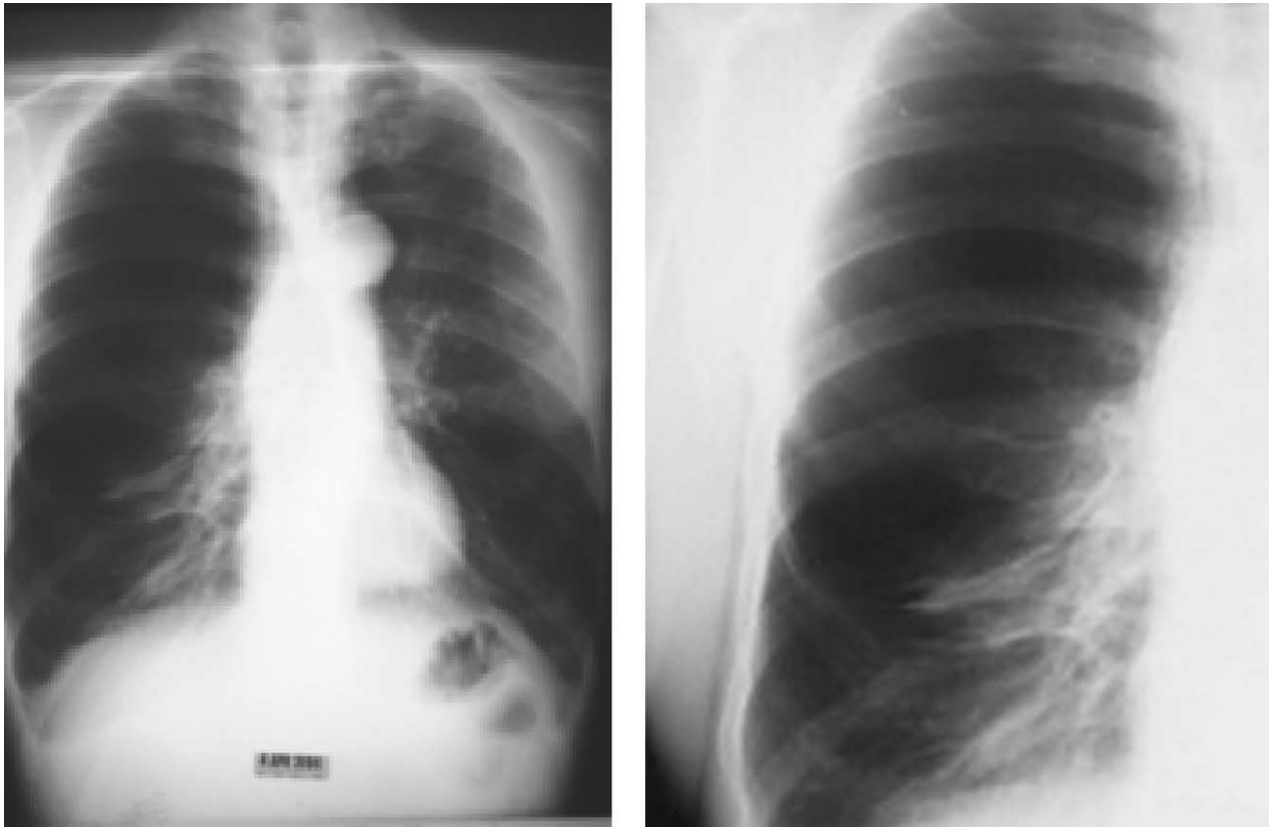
(a,b) Chest X-ray study showing hyperinflation with decreased lung markings throughout both lung fields but most dramatically on the right. However, no clearly identifiable pleural line is visible.
